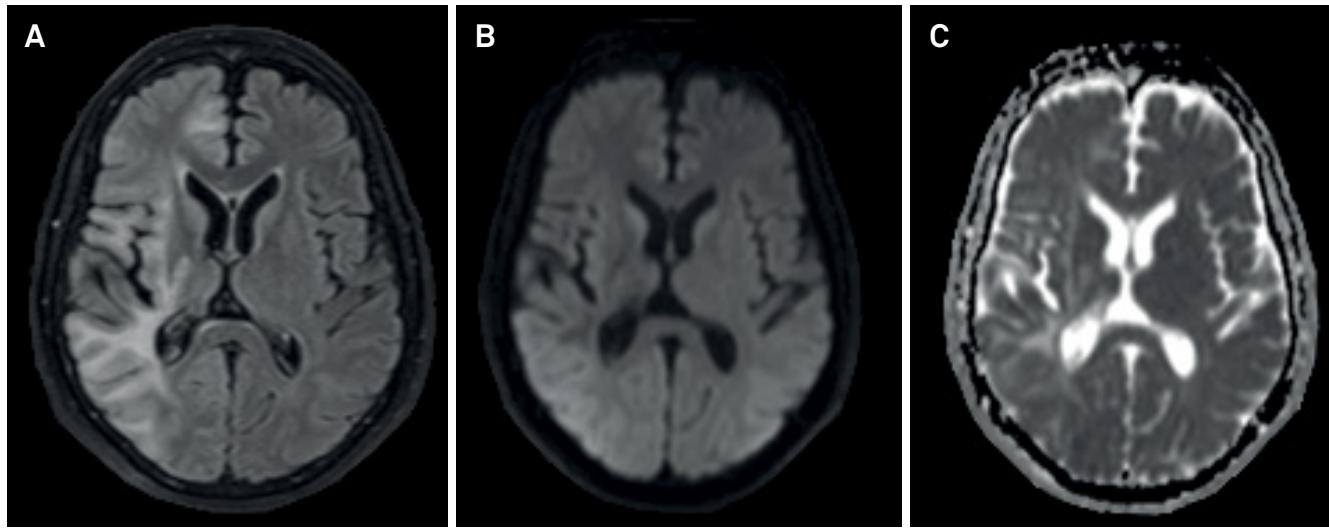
Brain MRI two weeks after resolution of the *epilepsia partialis continua* with antiepileptic drugs. FLAIR (A) image: previous residual aspect of tumefactive demyelinating lesion with hyperintensities in periventricular and subcortical white matter. DWI (B) and ADC map (C) without restricted diffusion. DWI: Diffusion weighted imaging; ADC: Apparent diffusion coefficient
